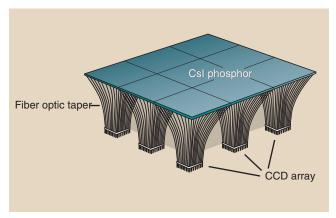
Charge-coupled devices (CCDs) can be tiled to receive the light from an area x-ray beam as it interacts with a scintillation phosphor such as cesium iodide (CsI).
